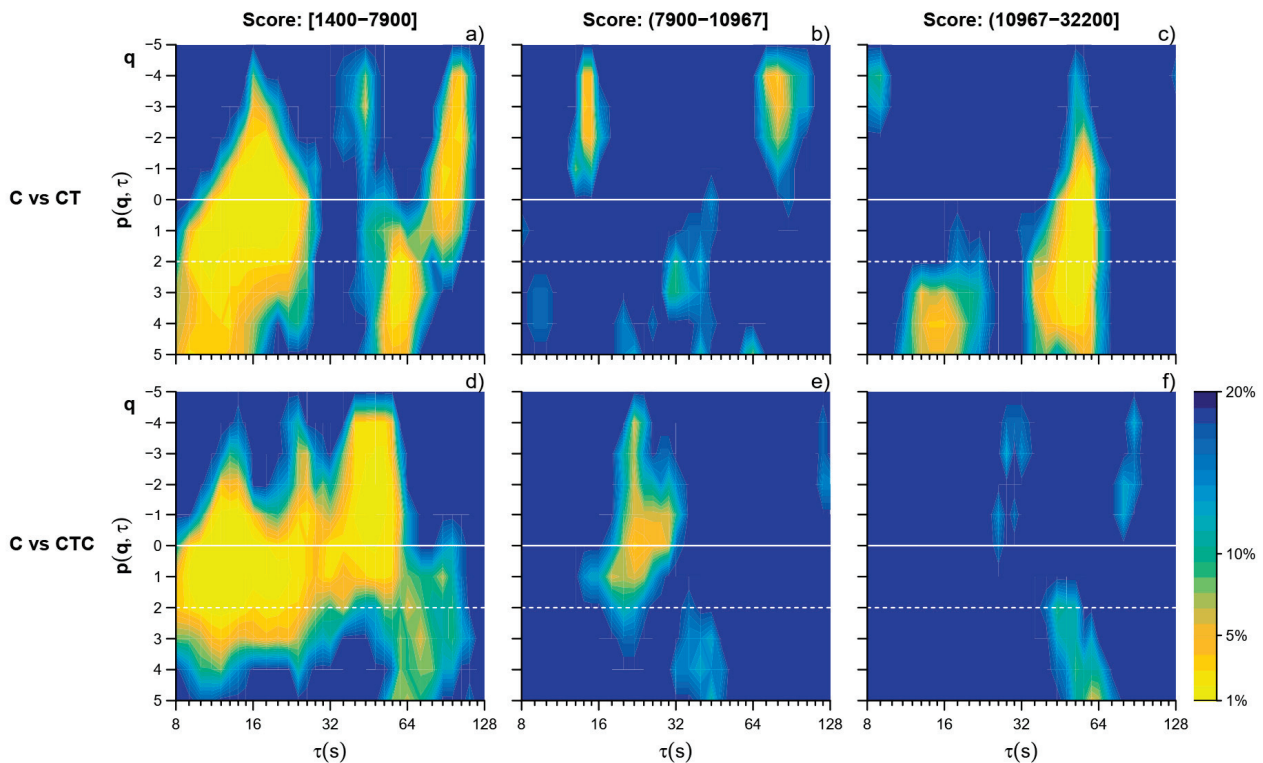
Wilcoxon p significance of the comparison of the MFMS-DFA coefficients between the reference C vs. CT and CTC by tertile of Tetris score. Color codes as in Figure 3 compare C vs. CT in the I (a), II (b), and III (c) tertile and C vs. CTC in the I (d), II (e), and III (f) tertile.
